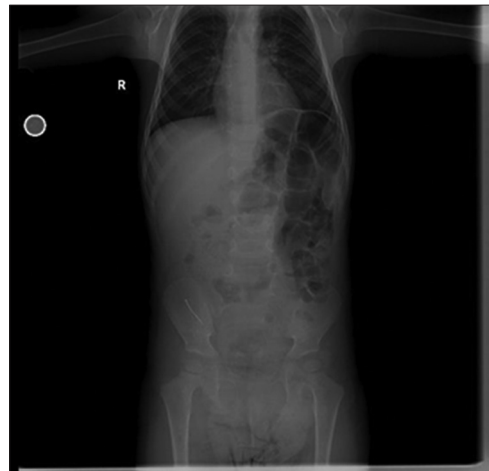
Abdominal radiography
